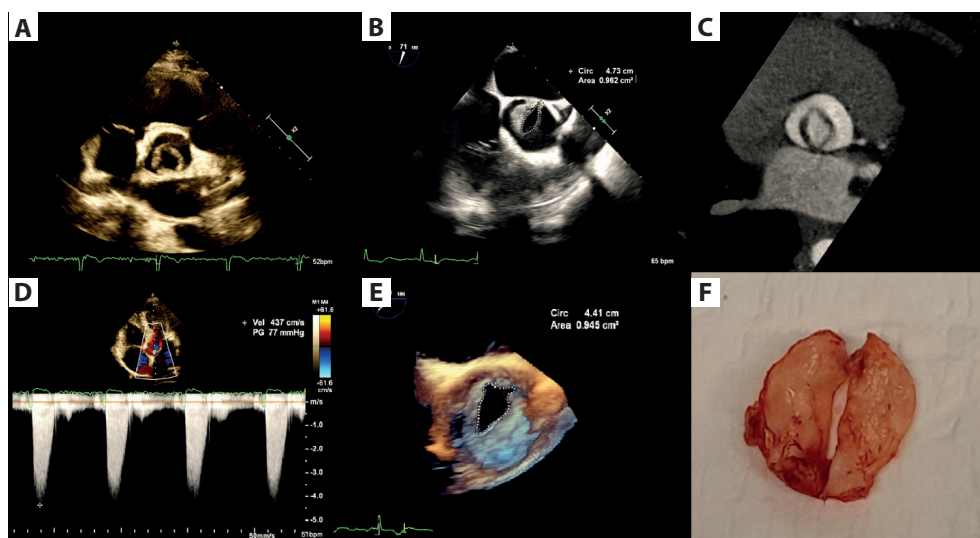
A. Unicuspid aortic valve (the arrow); short axis view, 2D TTE. B. Peak velocity >4 m/sec measured using continuous-wave Doppler, TTE. C. Measurement of an aortic-valve area using planimetric two-dimensional (2D) TOE. D. Measurement of an aortic valve area using planimetric three-dimensional (3D) TOE. E. CT image of the unicuspid aortic valve. F. The unicuspid aortic valve after cardiac surgery
